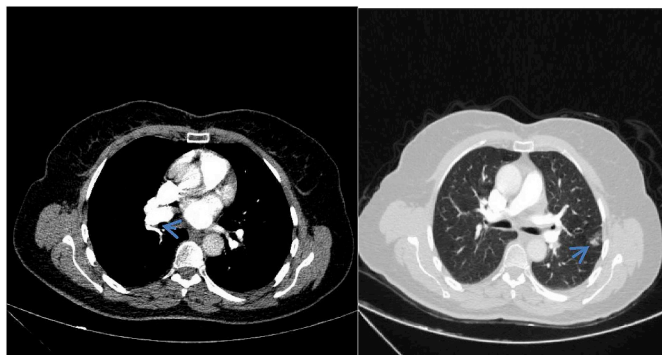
27-year-old woman with 1 year of all-day continuing cough, two and a half years ago traffic accident with fractures. CT pulmonary angiography shows pulmonary emboli in bilateral lower lobe artery (arrows).
